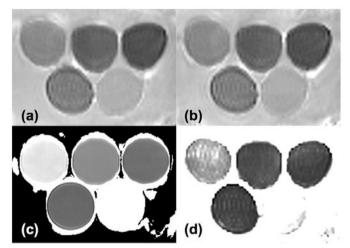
ADC (a,b) and T_2 (c,d) parametric maps from standard DWI (a) and T_2 measurements (c) and from Relax-DWI (ADC (b) and T_2 (d), respectively).
